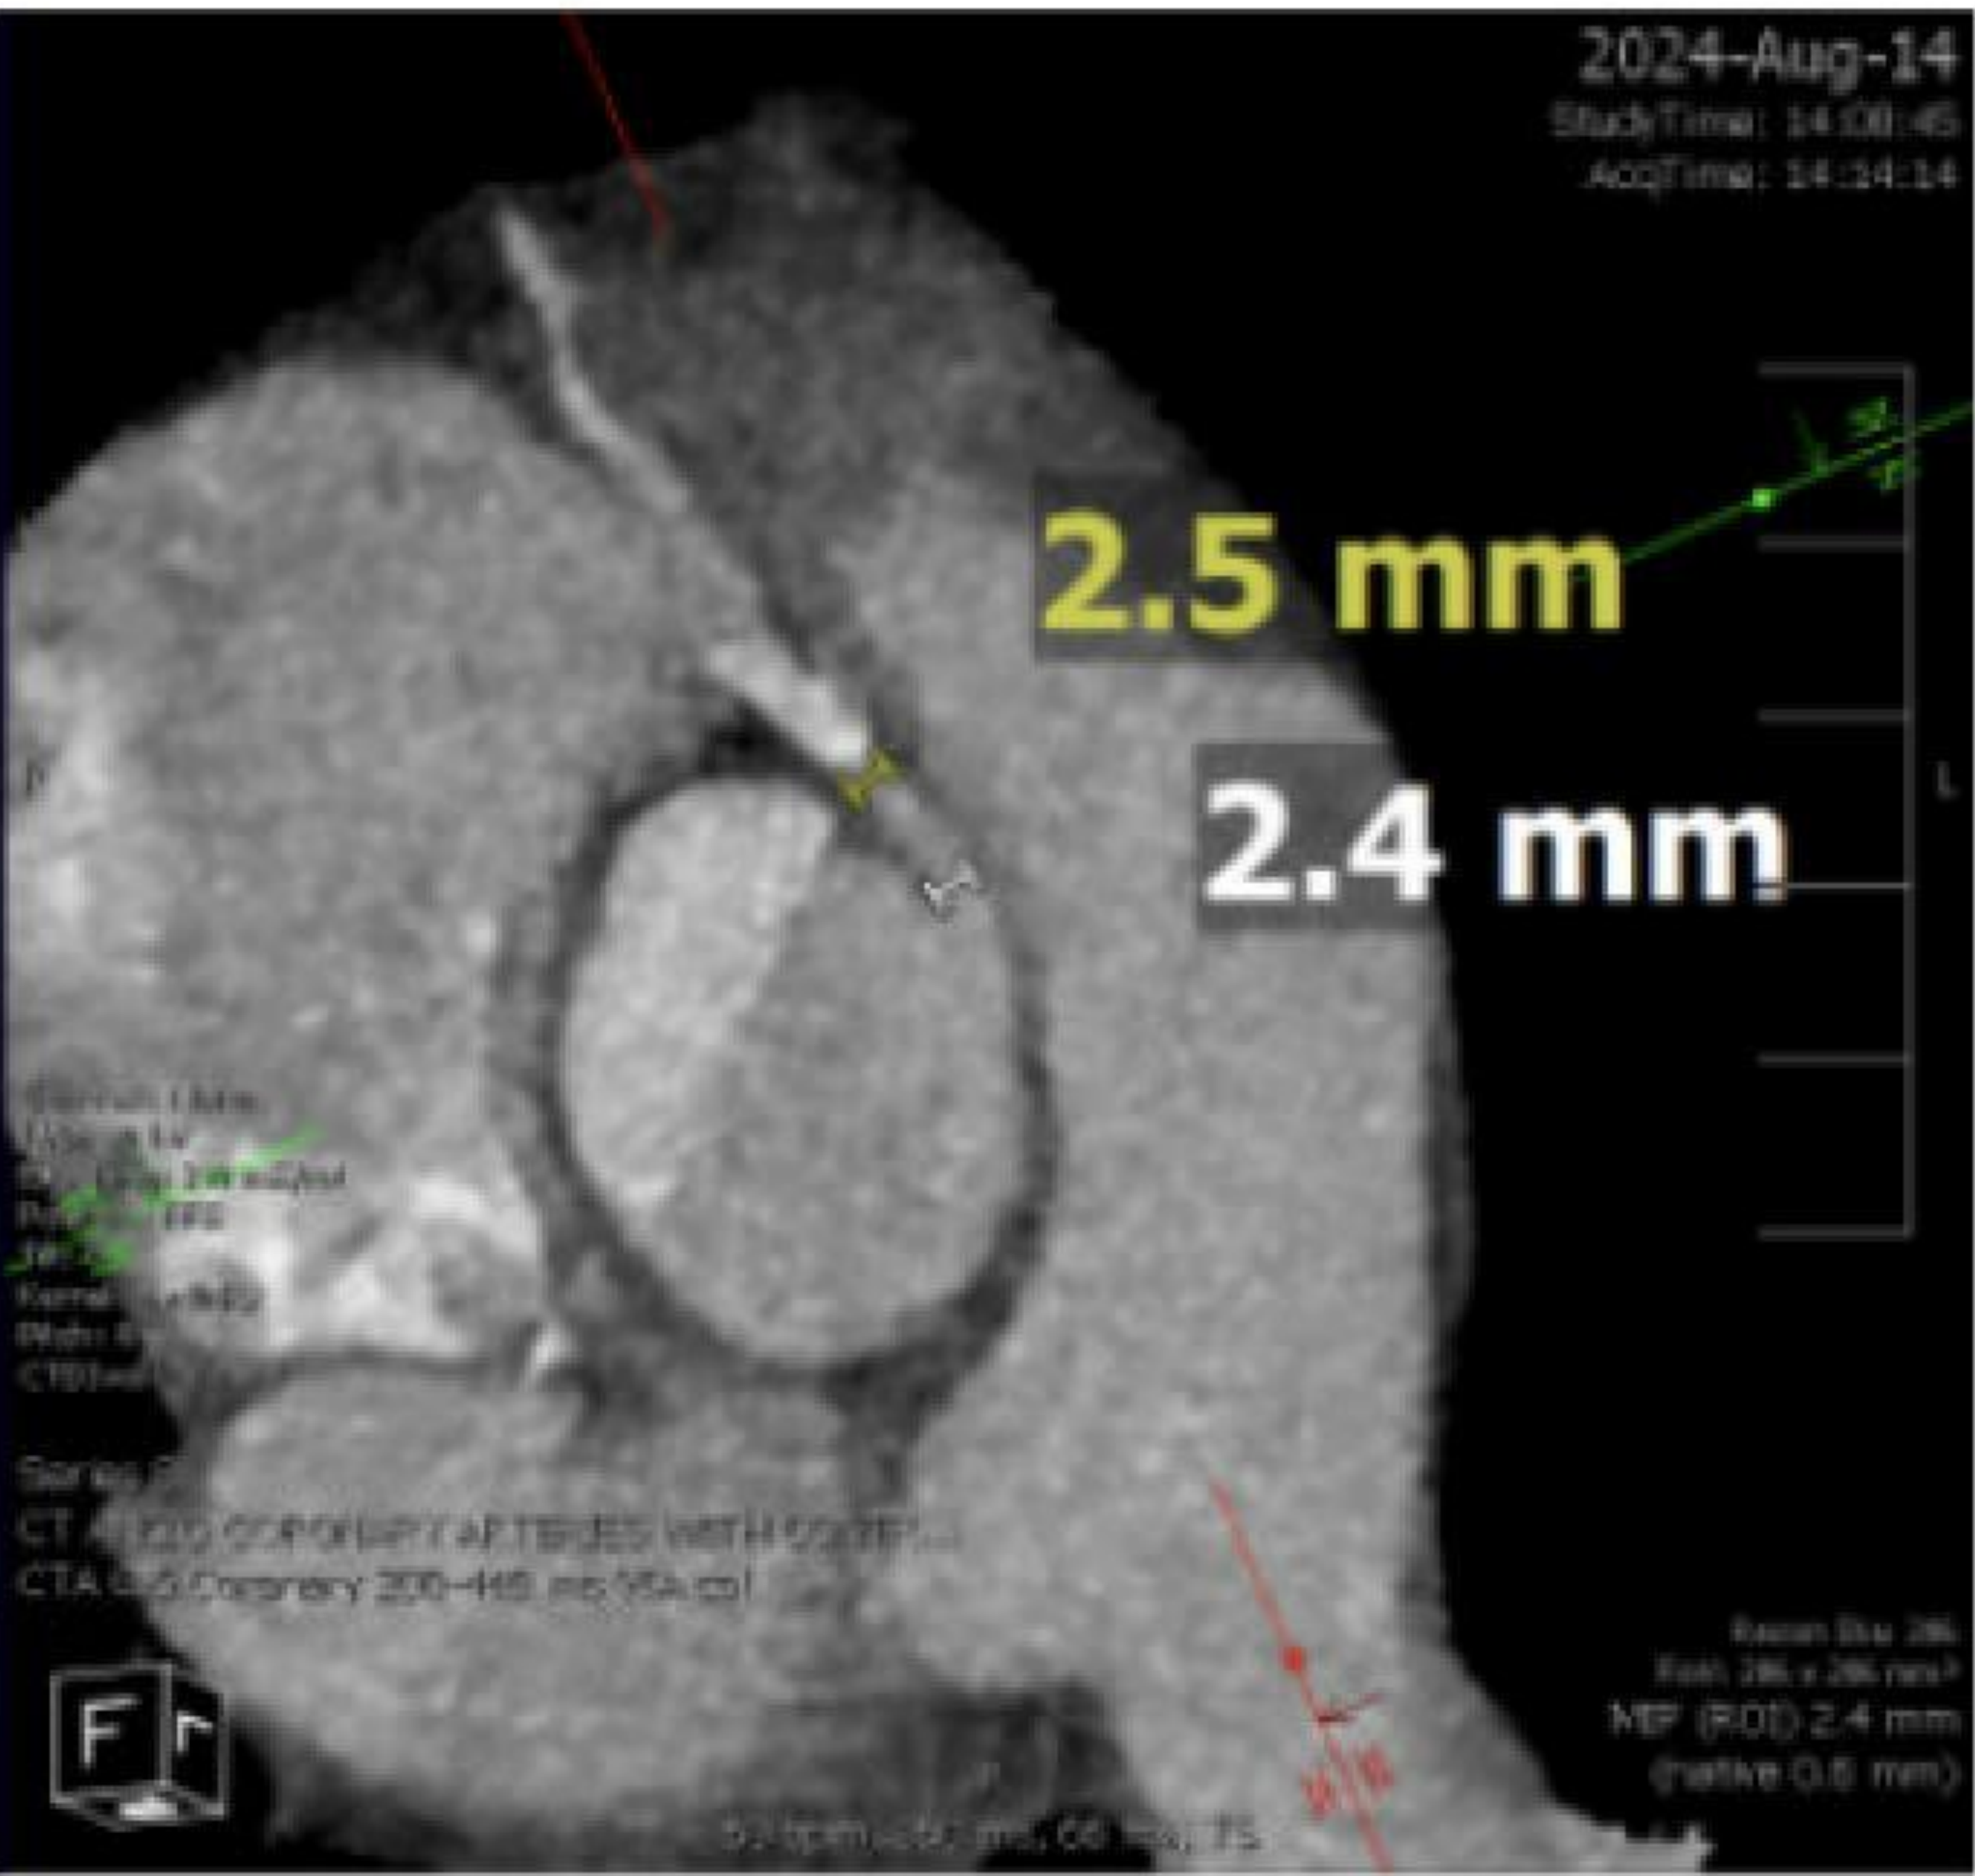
Preoperative Coronary CTA
